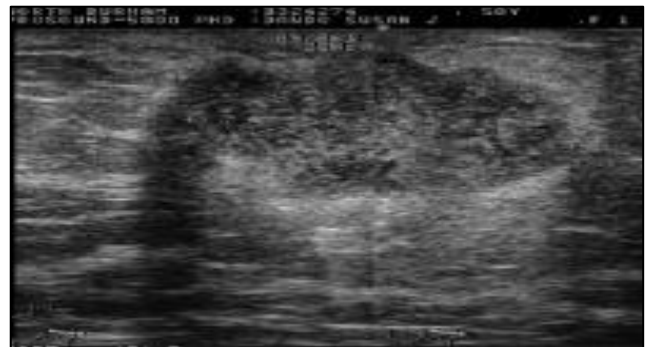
Ultrasound of the lesion (c) confirms a 5.2 cm complex hypoechoic mass lesion.
